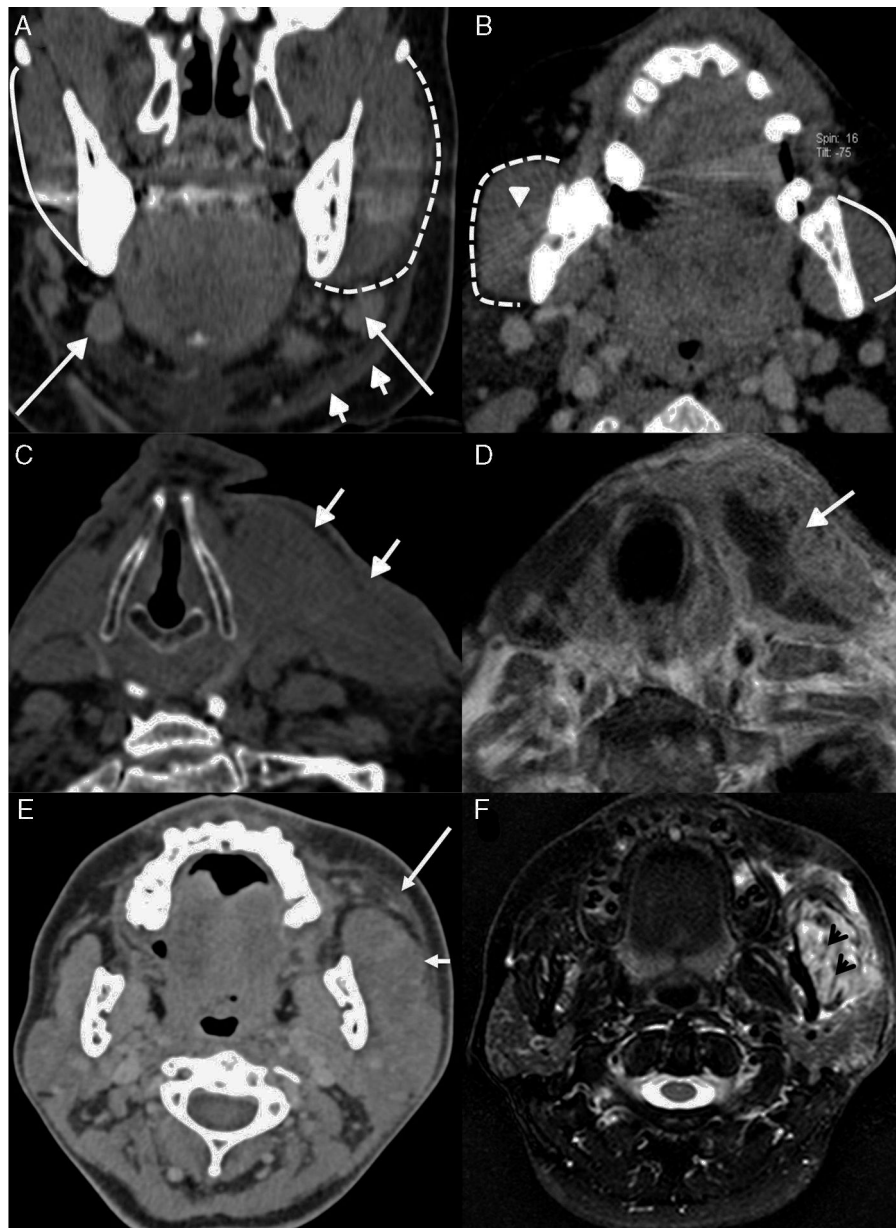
Muscular facial swelling. (A) Computed tomography (CT), coronal section with IV contrast. Suspicion of dental phlegmon. There is cellulitis (short arrows) and adenomegalia (long arrows) more significant in the left submandibular space secondary to a periodontal abscess of the 48th tooth (not shown). There is an increase in size and the uptake of the left masseter muscle is indicative of *myositis* (dotted outline) without clear images of abscesses (purulent content was extracted in the puncture). Compare with normal masseter muscle of the contralateral side (continuous outline). (B) CT, axial section with IV contrast. Patient with a prior history of dental phlegmon showing pain at admission in the malar region. There is myositis of the right masseter muscle (dotted outline) with evidence of a *small abscess* in the submasseteric space (arrowhead). On the left side, the muscle showed normal characteristics (continuous outline). (C) CT, axial section. Eighty-year-old man showing fluctuating left cervical swelling at admission. Absence of local warmth. The CT shows an increase in size and poor definition of the left sternocleidomastoid muscle (arrows). (D) T1-weighted MRI axial section with gadolinium of the same patient as in image C where an *intramuscular abscess* can be observed (white arrow). The microbiological study revealed tuberculosis. (E) CT, axial section with IV contrast. Woman found unconscious in a fire on the left decubitus position, with an important left facial swelling. The image shows an increase in size of the left masseter muscle (short arrow) and perimuscular cellulitis (long arrow). (F) T2-weighted MRI axial section with fat saturation of the same patient as in image E, where a type II *myositis of the masseter muscle* is confirmed, confirmed by its spotted pattern (short, black arrows).
